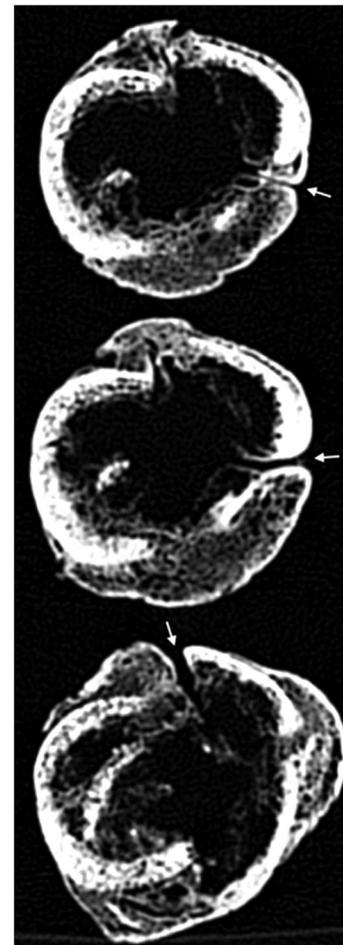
Computerized tomography (CT) multiplanar reconstruction of axial views (three levels) of the lower diaphysis of the right femur (arrows showing three distinct cloacae)
